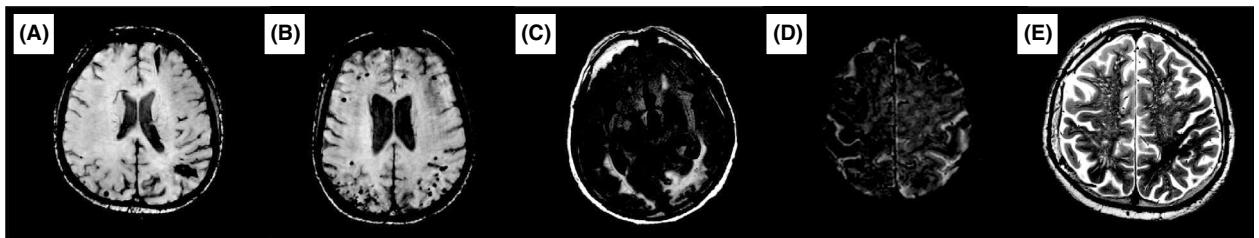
MRI markers of CAA. (A) Cortical intracerebral haemorrhages. (B) Cortical and cortico-subcortical microhaemorrhages. (C) Posterior white matter hyperintensities (WMH). (D) Cortical superficial siderosis (cSS). (E) White matter perivascular spaces (PVS). (A, B, D) T2*-weighted gradient recalled echo (T2*-GRE) MRI sequences; (C) fluid-attenuated inversion recovery (FLAIR) MRI sequence; (E) T2-weighted MRI image. (A, B, E) 3T MRI; (C, D) 1.5T MRI.
